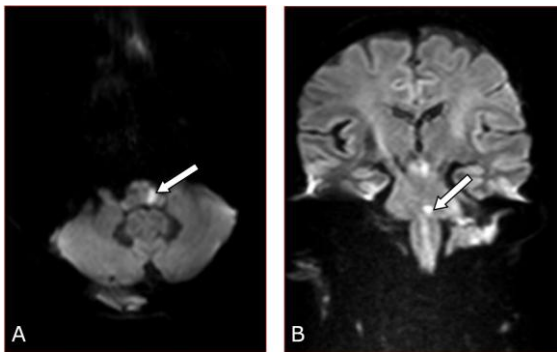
Acute left pons infarction in a patient aged 70 years suffered from dysphasia; A) Standard axial-section 5 mm DWI; B) Thin-section coronal 3 mm DWI. The lesion is more delineated in the latter sequence image
